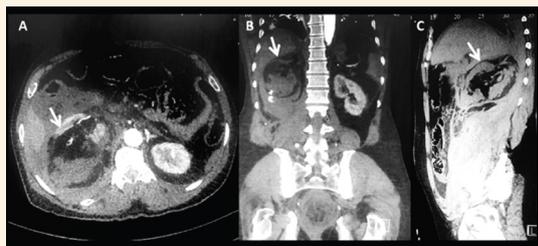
Abdominal computed tomography scan with contrast in (A) axial, (B) coronal and (C) sagittal views showing actively bleeding right renal angiomyolipoma and haematoma.
